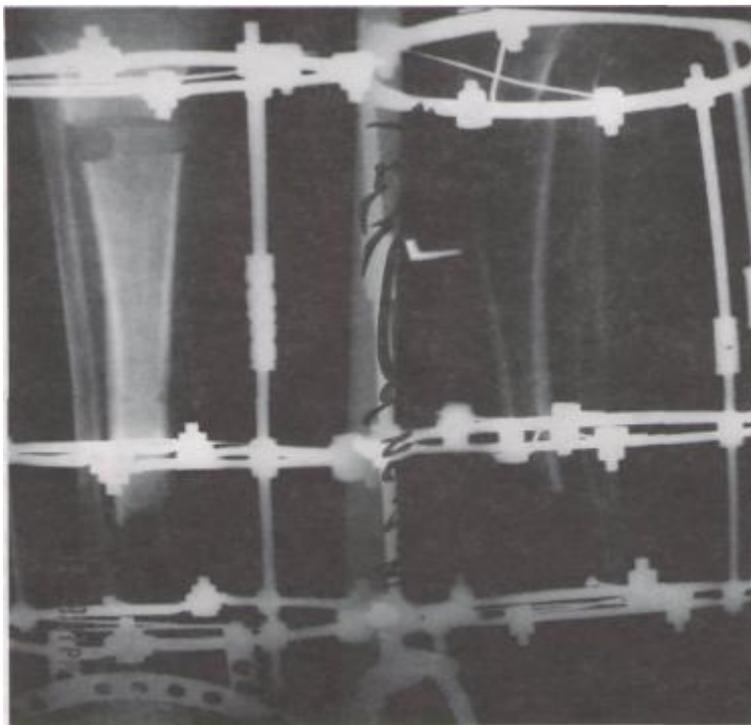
Patient X, 21 years old. Dynamic radiograph of the left tibia.
